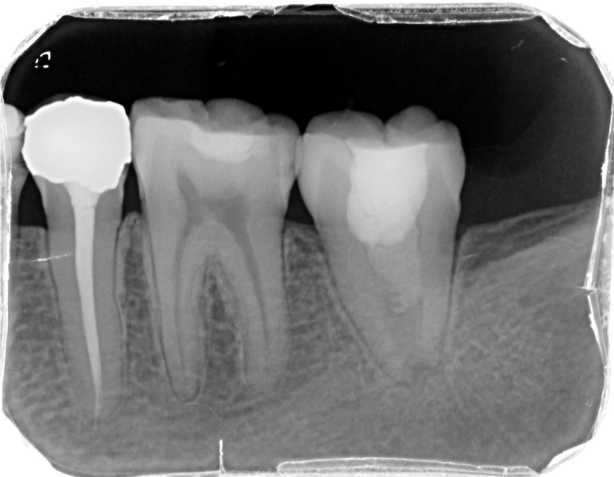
6-month follow-up radiograph
